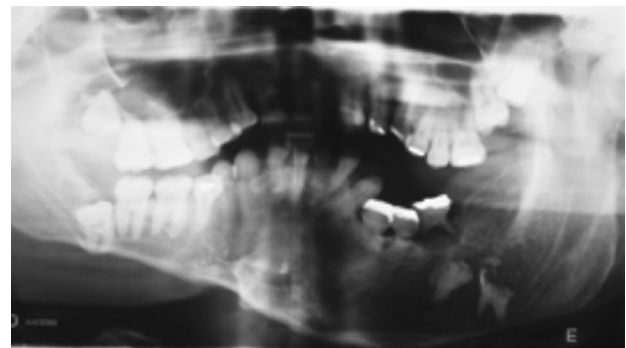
Panoramic radiography of a patient with Proteus syndrome. Note the asymmetric overgrowth, irregular occlusal plane, and the tooth retention
